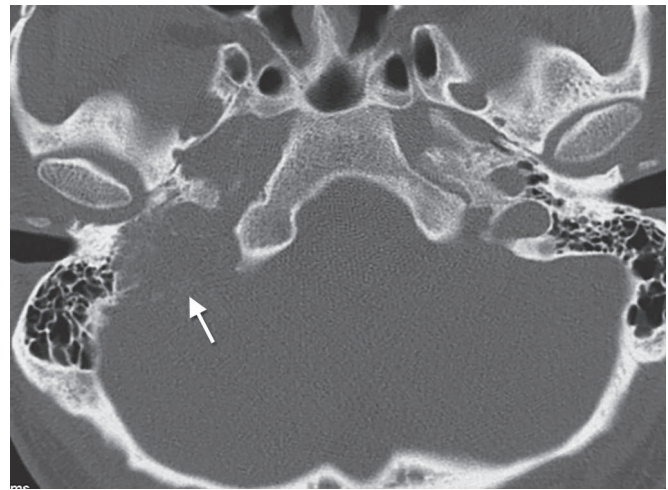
High-resolution computed tomography of the temporal bone, axial views, demonstrating a lesion extending from the jugular bulb into the posterior fossa consistent with a glomus jugulare. Note, the moth-eaten appearance and the irregular borders.
